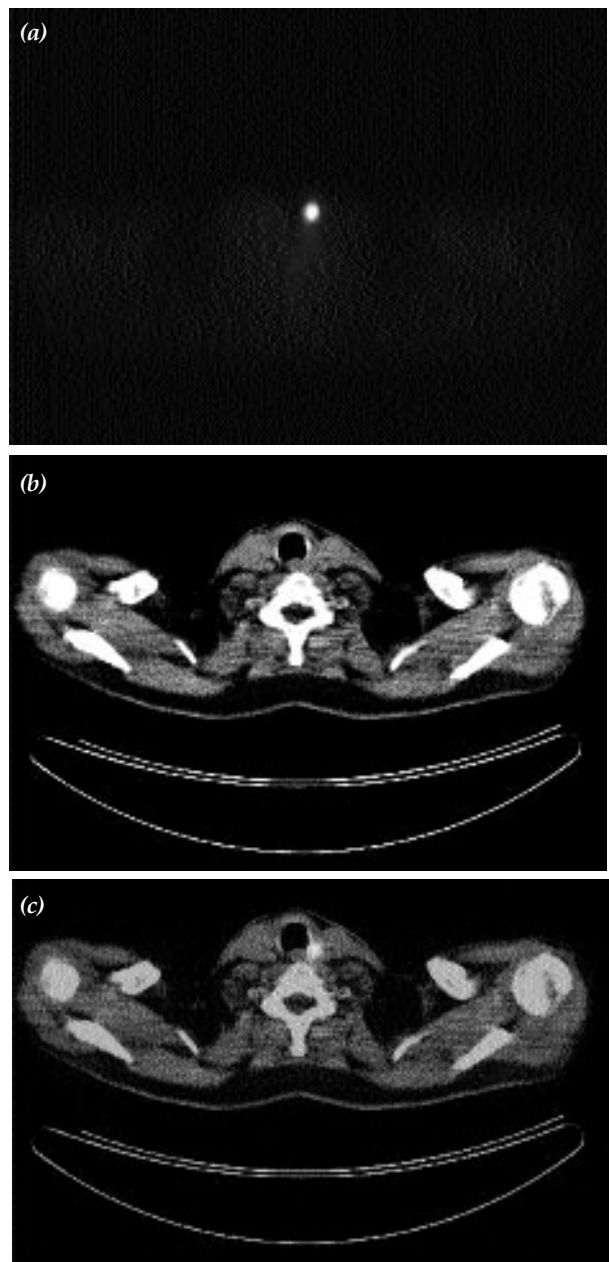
(a) PET, (b) CT, and (c) DTC fused images.
